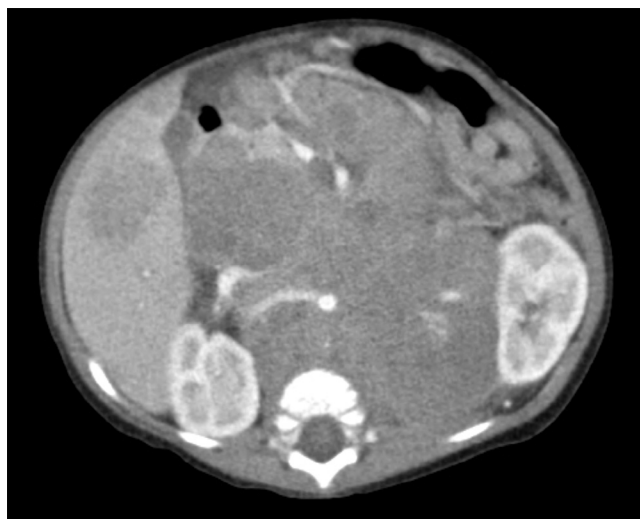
Axial computed tomography of the abdomen shows large soft tissue mass encasing the arterial vasculature and exhibiting significant mass effect on both kidneys, the aorta, and the inferior vena cava. Additionally, there is a hypodense metastatic lesion noted within the right lobe of the liver.
